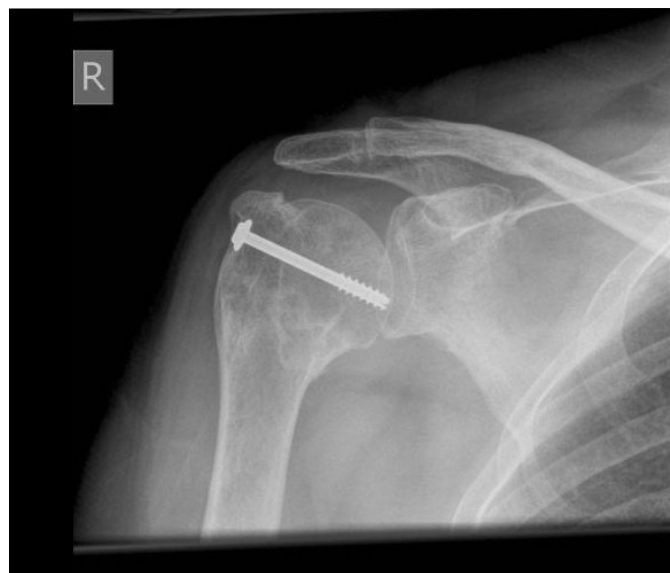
Initial post-operative radiograph following cannulated screw fixation of the greater tuberosity without adequate reduction; the tuberosity is malunited in a superiorly migrated position
